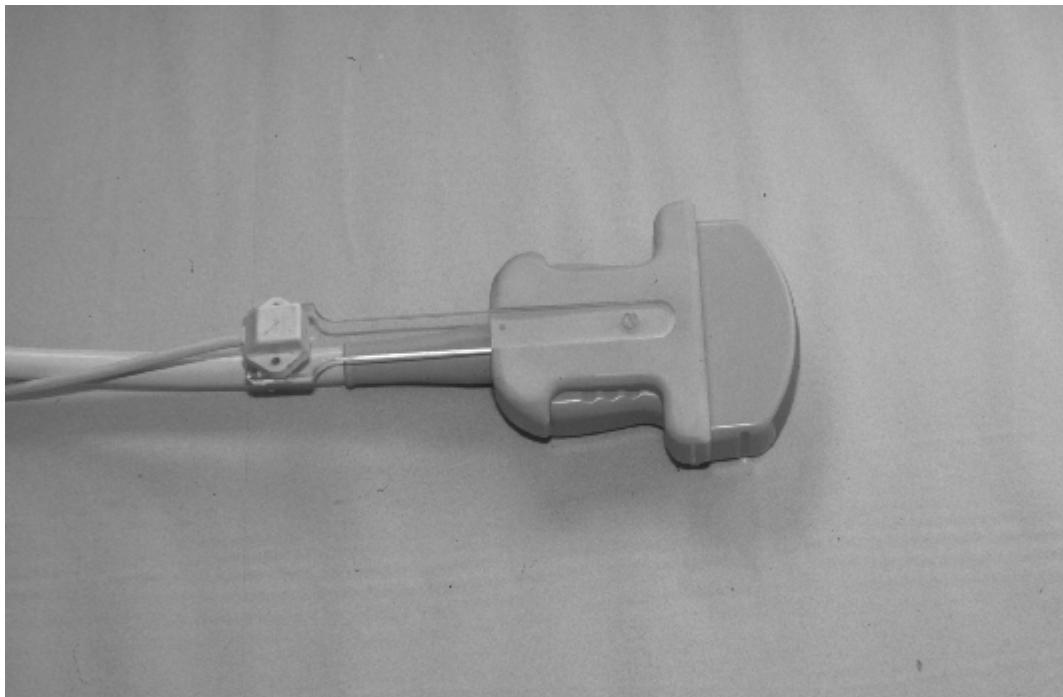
Polhemus sensor attached to the ultrasound transducer.
